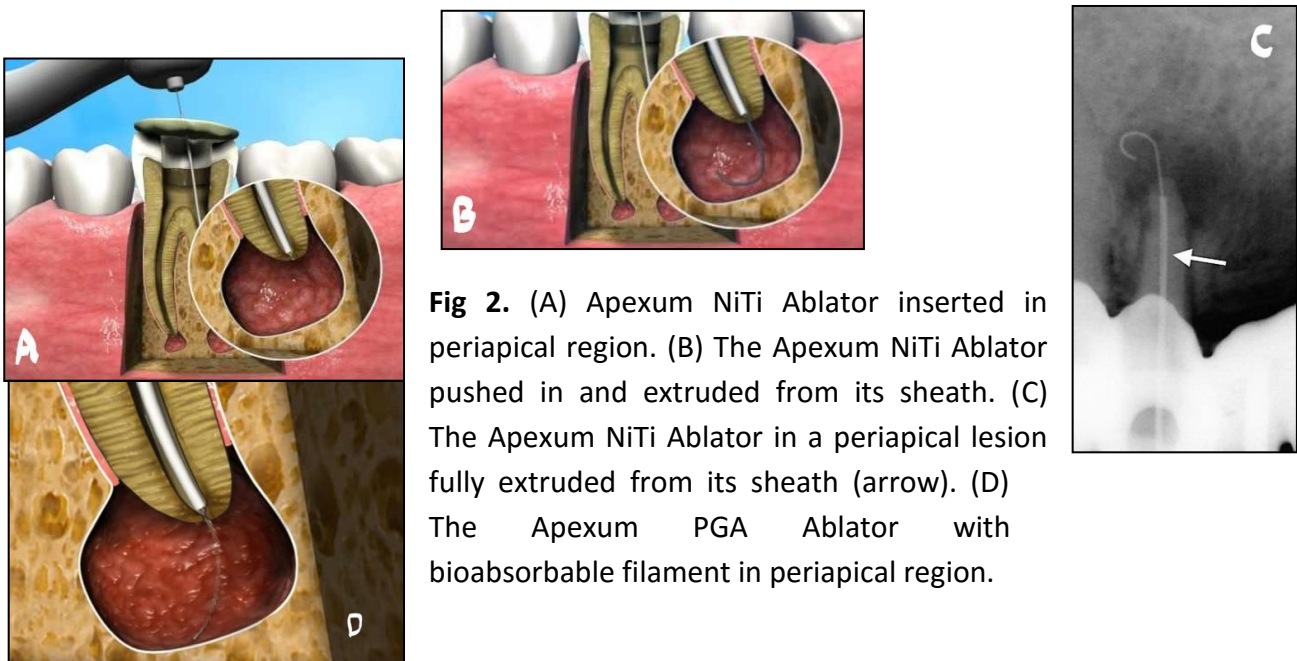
(A) Apexum NiTi Ablator inserted in periapical region. (B) The Apexum NiTi Ablator pushed in and extruded from its sheath. (C) The Apexum NiTi Ablator in a periapical lesion fully extruded from its sheath (arrow). (D) The Apexum PGA Ablator with bioabsorbable filament in periapical region.
